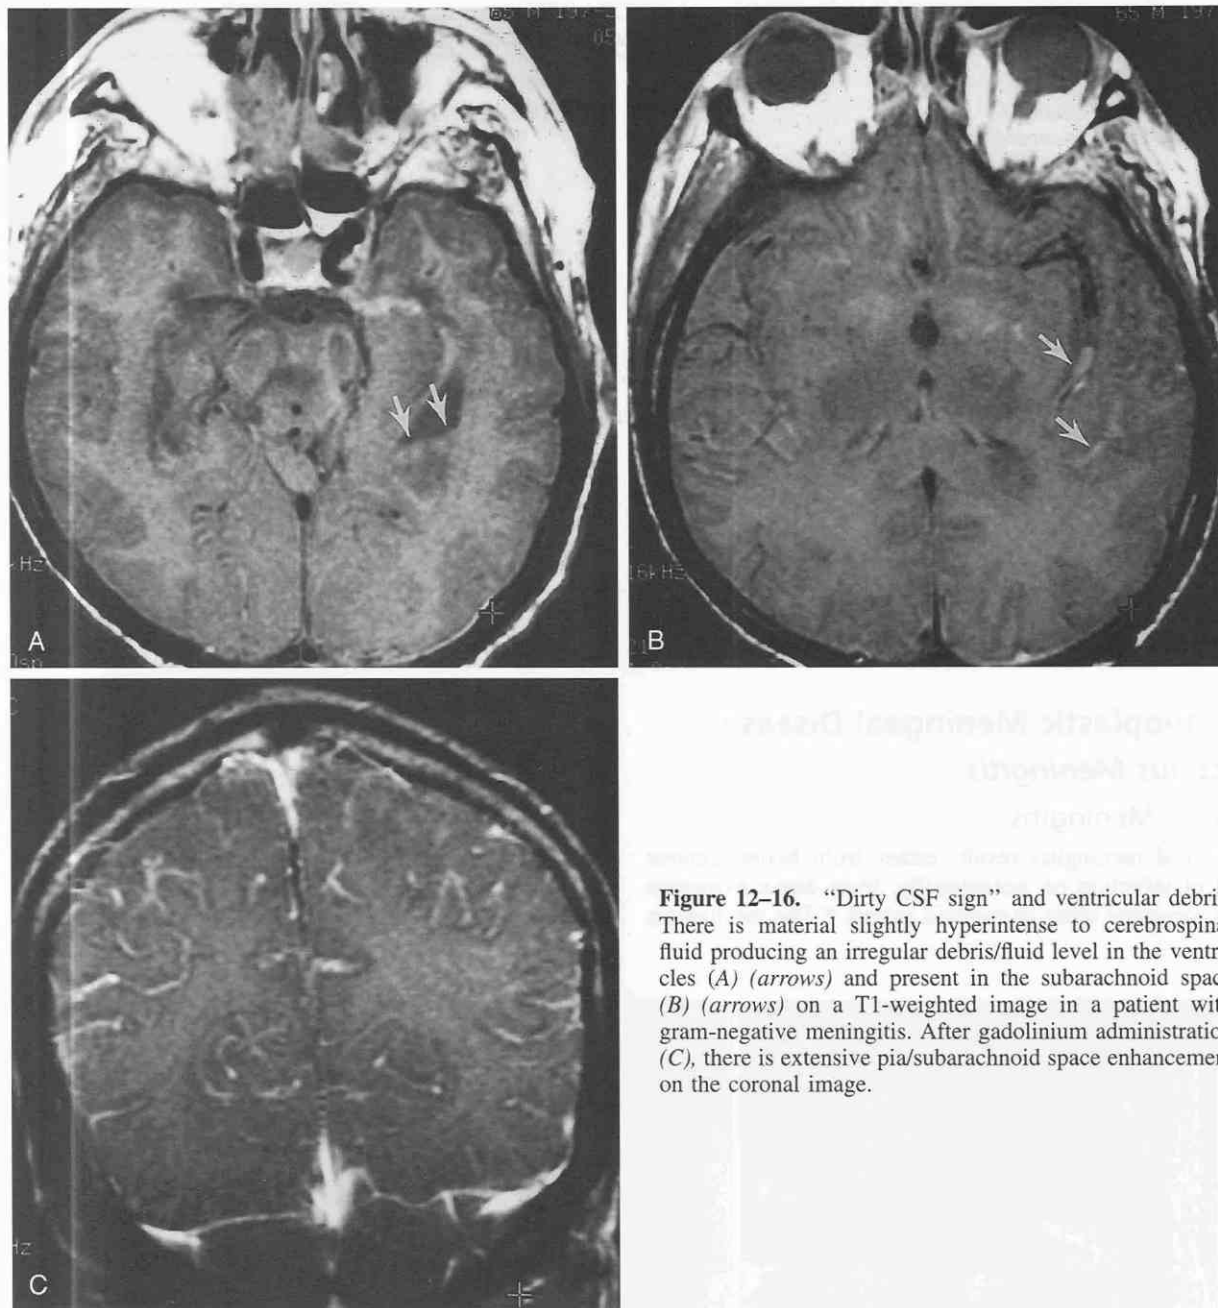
“Dirty CSF sign” and ventricular debris. There is material slightly hyperintense to cerebrospinal fluid producing an irregular debris/fluid level in the ventricles (A) (arrows) and present in the subarachnoid space (B) (arrows) on a T1-weighted image in a patient with gram-negative meningitis. After gadolinium administration (C), there is extensive pia/subarachnoid space enhancement on the coronal image.
